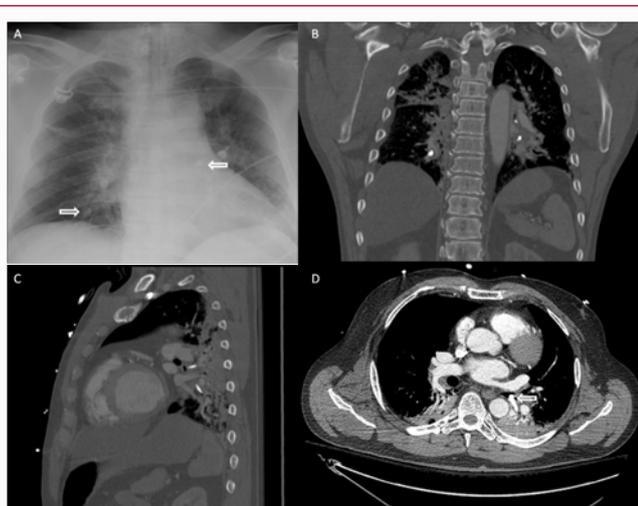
AP CXR (1A) and CT chest demonstrate teeth in RLL and LL (1B, 1C, 1D).
